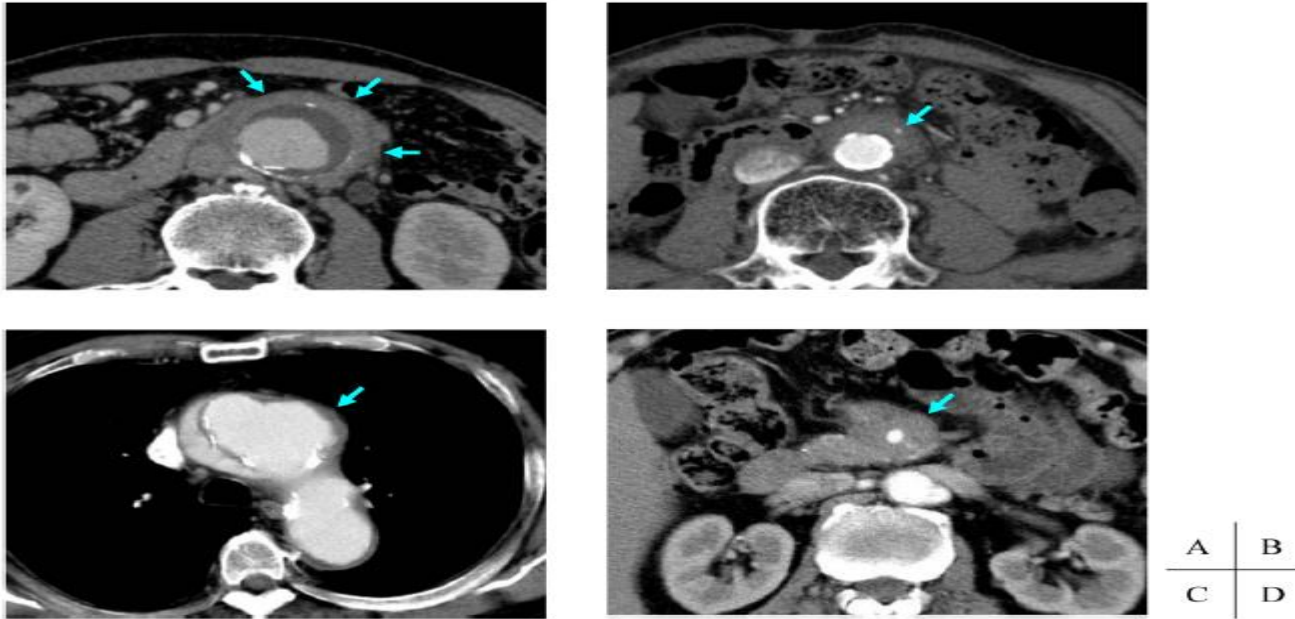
Contrast-enhanced computed tomography (CT). (A) IgG4-related inflammatory abdominal aortic aneurysm. The aneurysmal wall shows severe thickening, and it looks like a soft tissue mass surrounding the aorta. An enhanced thickening of the adventitia forms 'mantle sign' (arrows). (B) IgG4-related periaortitis. Marked thickening of the aortic wall without aneurysmal change is shown. The inferior mesenteric artery penetrates the lesion without stenosis (arrow). (C) IgG4-related disease of the thoracic aorta. CT shows a saccular aneurysm with a mild wall thickening (arrow). (D) IgG4-related disease of the superior mesenteric artery. CT shows a soft tissue mass surrounding the artery (arrow).
